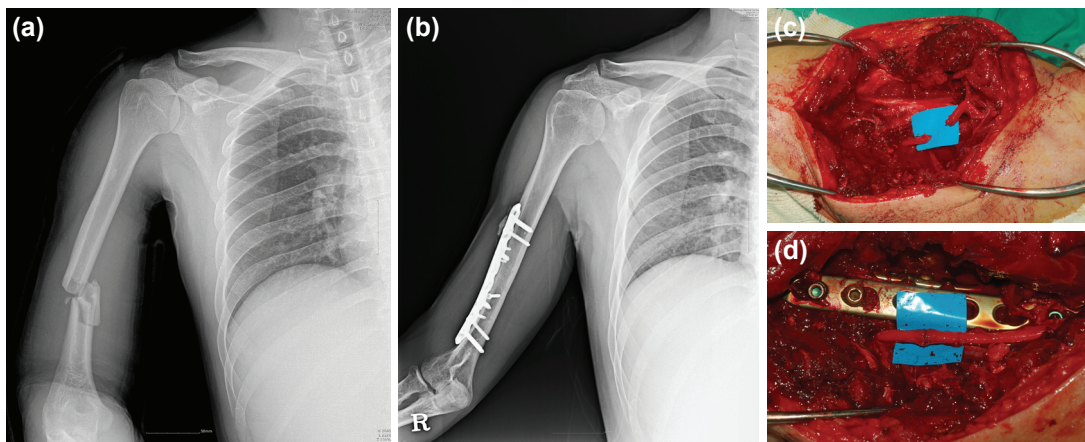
A 35-year-old injured in a motor cycle accident with humeral shaft fracture with middle butterfly fragment. (a) Preoperative radiograph demonstrating displaced fracture on middle-distal humeral shaft. (b) Postoperative radiograph of patients who underwent open reduction and plate fixation. (c) Intraoperative inspection of the radial nerve showed complete transection. (d) Neurolysis and perineural neurorraphy performed.
